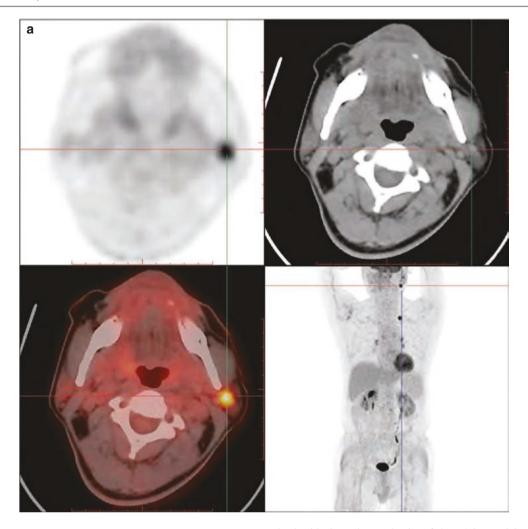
¹⁸F-FDG PET/CT images of Warthin tumor of the left parotid gland. (a–c) PET/CT images of hypermetabolic nodules in the left parotid gland. PET/CT showed that there was a round, slightly high-density, small nodule shadow in the lower pole of the left parotid
